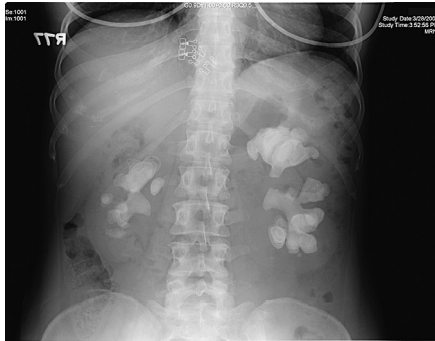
Plain film of a patient with bilateral staghorn calculi composed entirely of struvite. This patient had a 15-year history of recurrent urinary tract infections (UTIs). (From Wein A, et al. Campbell-Walsh urology. 9th ed. Philadelphia: Saunders, 2007, Fig. 43-9.)
